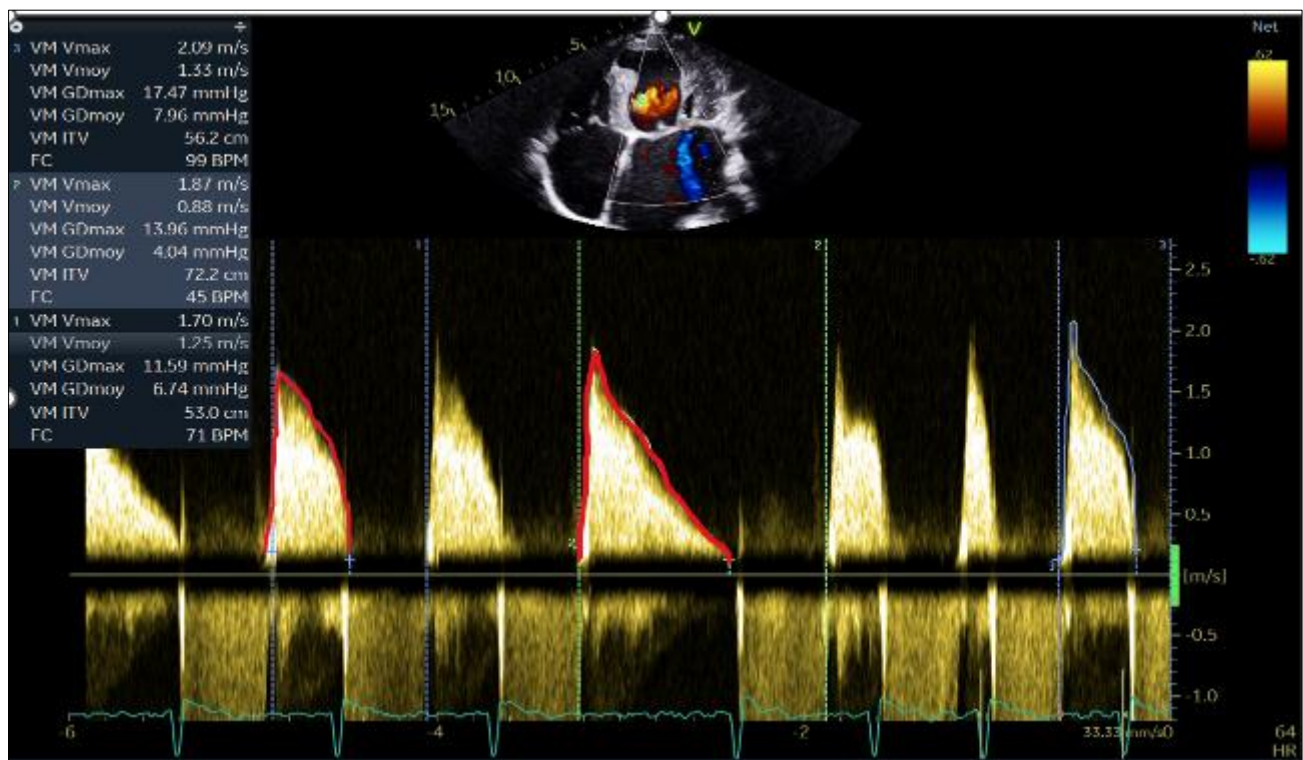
Measuring the mean trans-mitral gradient with continuous Doppler
